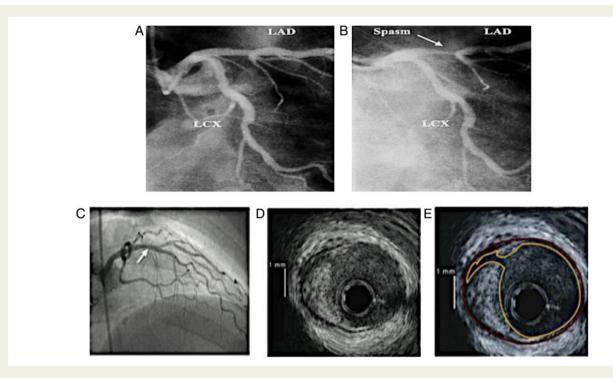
Epicardial causes of MINOCA. (A and B) Acute coronary artery spasm of the left anterior descending coronary artery (LAD) (white arrow) induced by intra-coronary ergonovine test. (C-E) Representative angiographic and intra-vascular ultrasound (IVUS) of plaque disruption. The site of plaque rupture or ulceration is marked with an arrow (C); the right side for the IVUS image (E) shows the outline of the luminal border (yellow) and external elastic lamina (red) corresponding to the IVUS image on left side (D).
